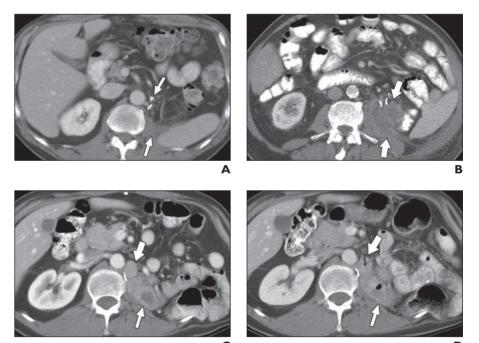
Local recurrence after nephrectomy as seen on CT.
